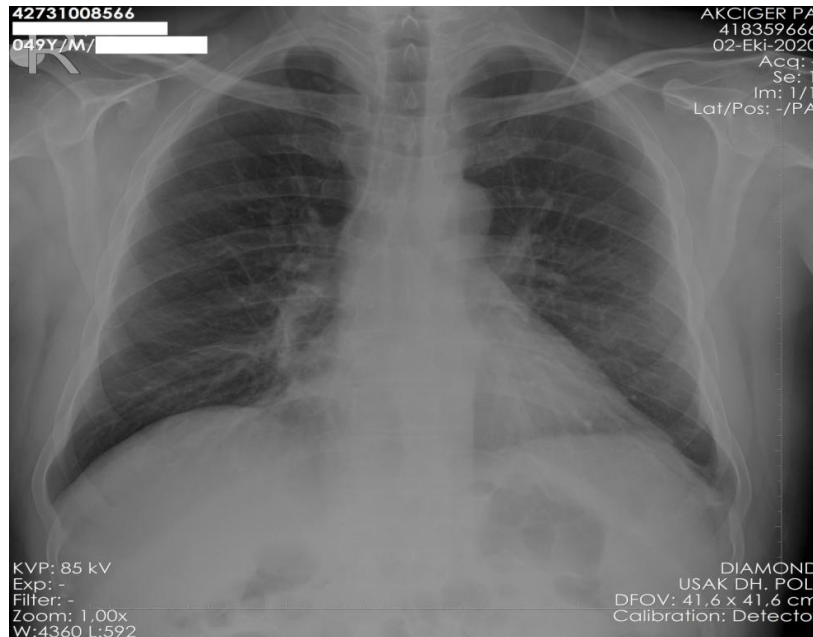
Control chest x-ray for perforation ecartation
